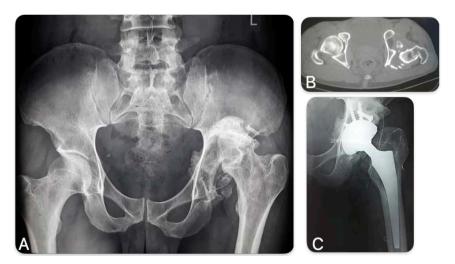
(A): initial radiological image showing the high posterior dislocation associated with a fracture of the roof and the posterior wall of the acetabulum; (B): initial CT image confirming the dislocation and fracture of the posterior wall of the acetabulum; (C): post-operative radiological control showing total hip prosthesis with screwed bone graft from the posterior wall.
